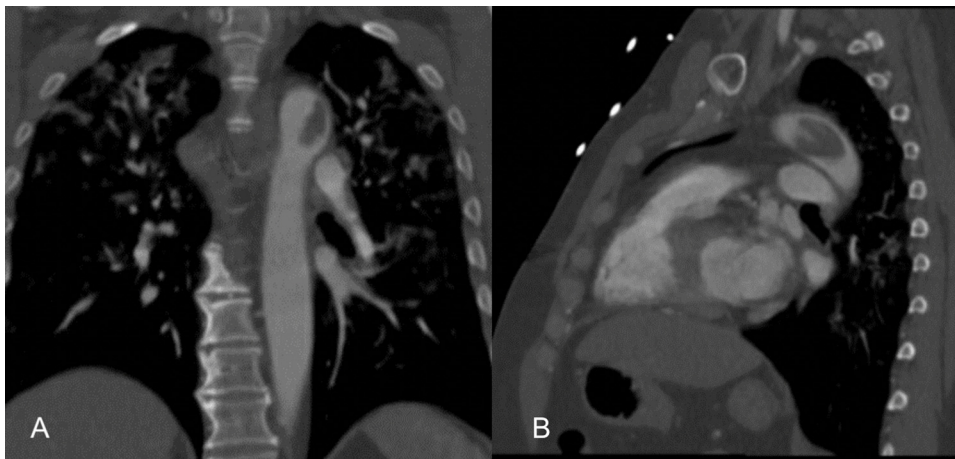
Coronal (A) and sagittal (B) views from a computed tomography angiography scan demonstrating a nonocclusive free-floating mural thrombus in the distal aortic arch.
